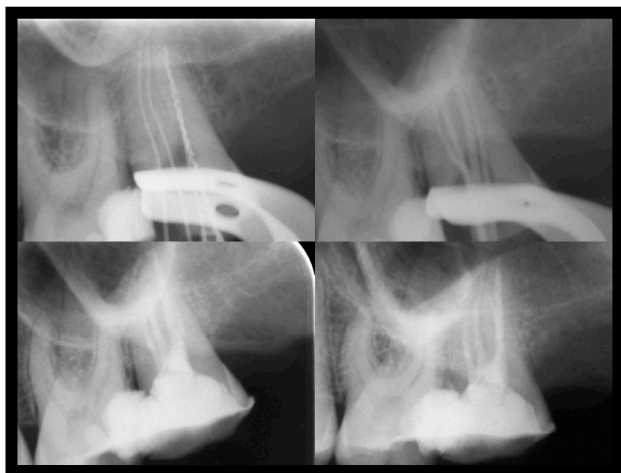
Treatment radiographs, 15. Mar. 2012
